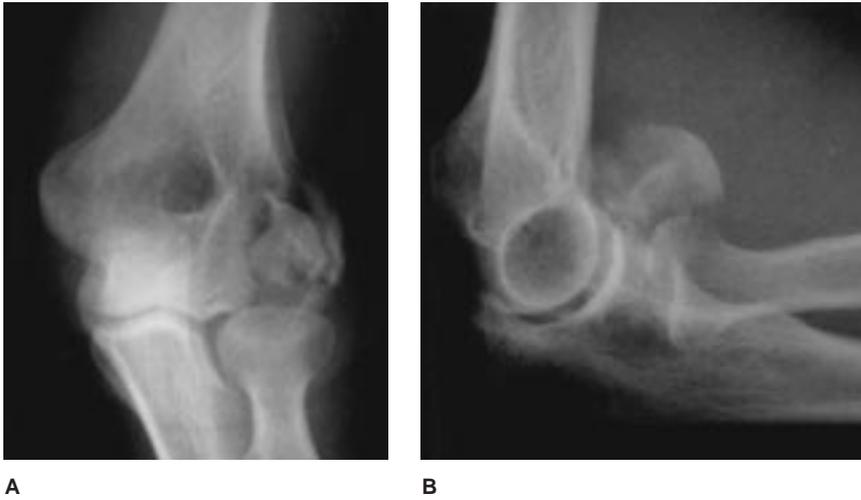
Anteroposterior (A) and lateral (B) radiographs of a 69-year-old woman with a fracture-dislocation of the elbow show a severely comminuted fracture of the capitellum.
